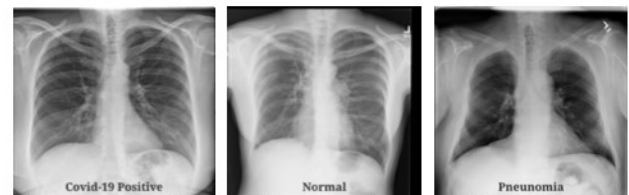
Sample chest X-Ray images used in the model
